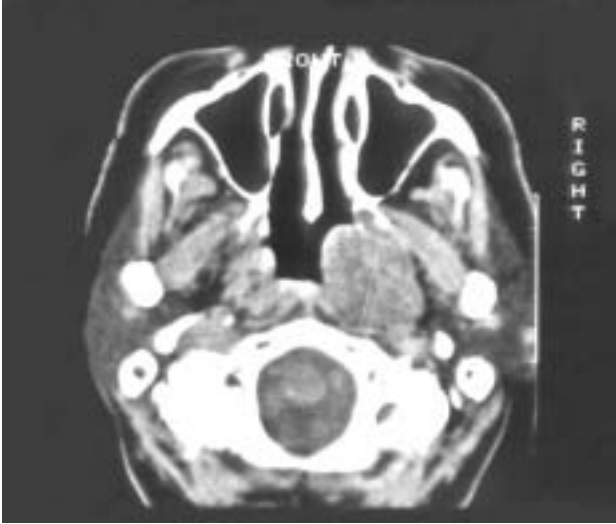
CT of epipharynx performed three years after the diagnosis shows the tumor mass with diameters 4.8 x 3.4 x 4.0 cm.
